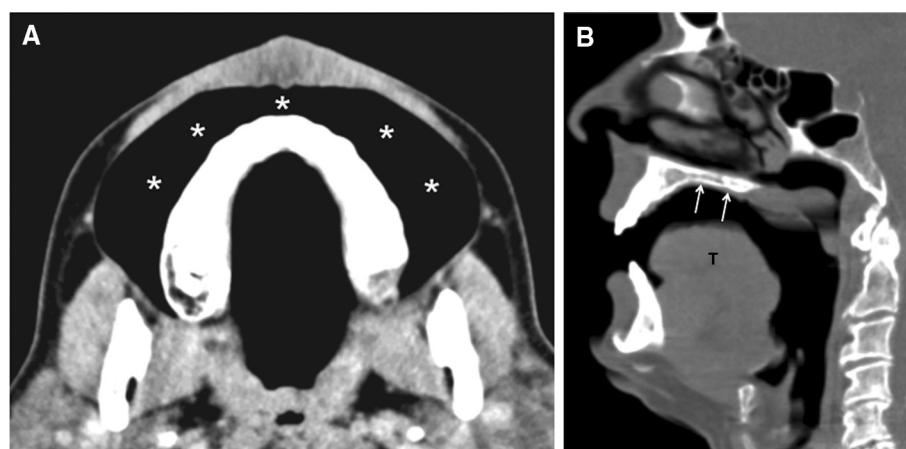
“Puffed-cheek” computed tomography (CT) scan: multiplanar reconstruction (MPR) image obtained at the level of the superior dental arch along the axial plane (A). Superior oral vestibule (asterisks). “Open-mouth” CT scan: MPR image obtained along the sagittal plane (B). Hard palate (arrows). T = tongue.
